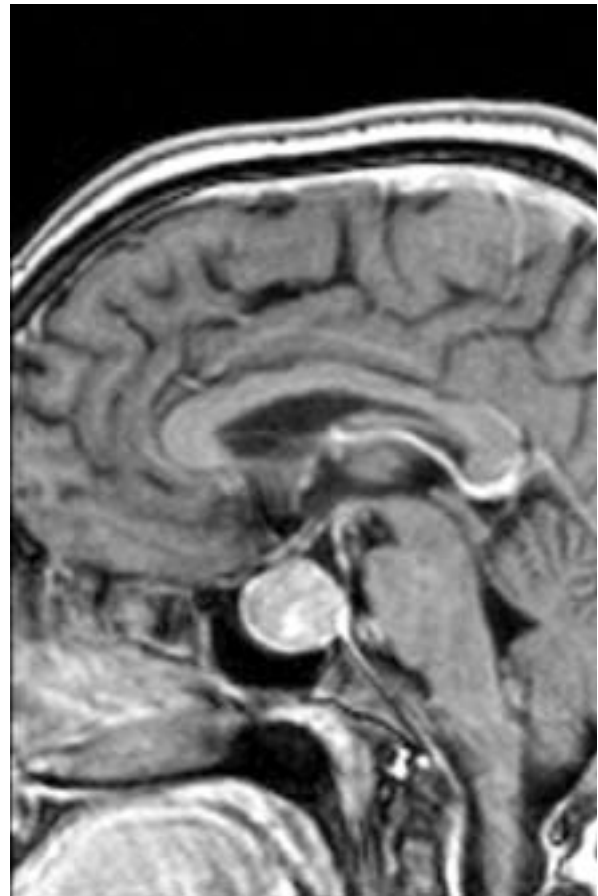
Sagittal MR imaging scan of the brain. A solid, well-demarcated, homogeneously enhancing, noninvasive mass in the pituitary region.
